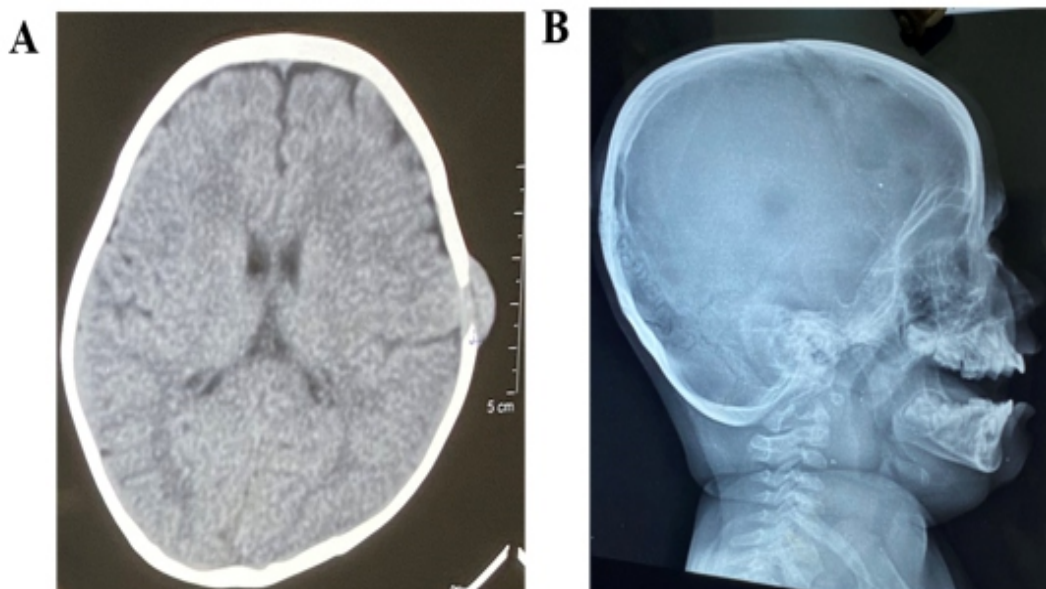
(A) CT scan of the head showing punched-out lytic lesion in the parietal bone with associated soft tissue swelling in Langerhans Cell Histiocytosis; (B) Lateral skull X-ray showing multiple punched-out lytic lesions in the calvarium consistent with Langerhans Cell Histiocytosis
